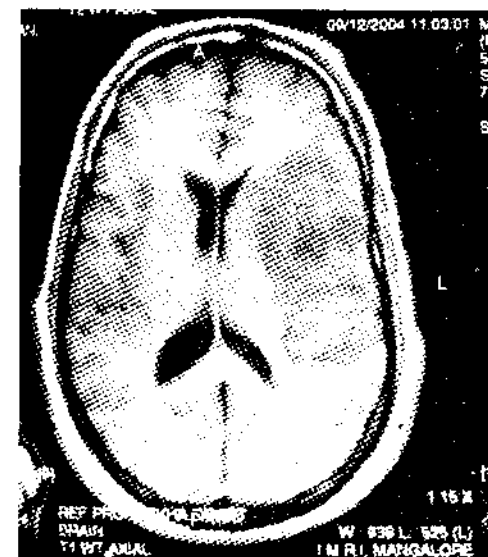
CT scan of a patient with meningioma
